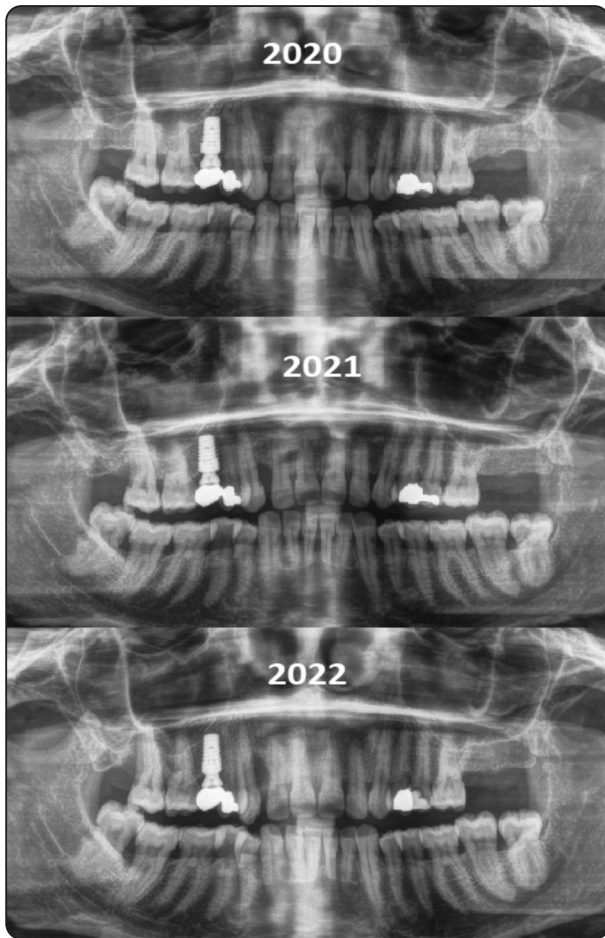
Previous panoramic X-rays 2020,2021,2022
